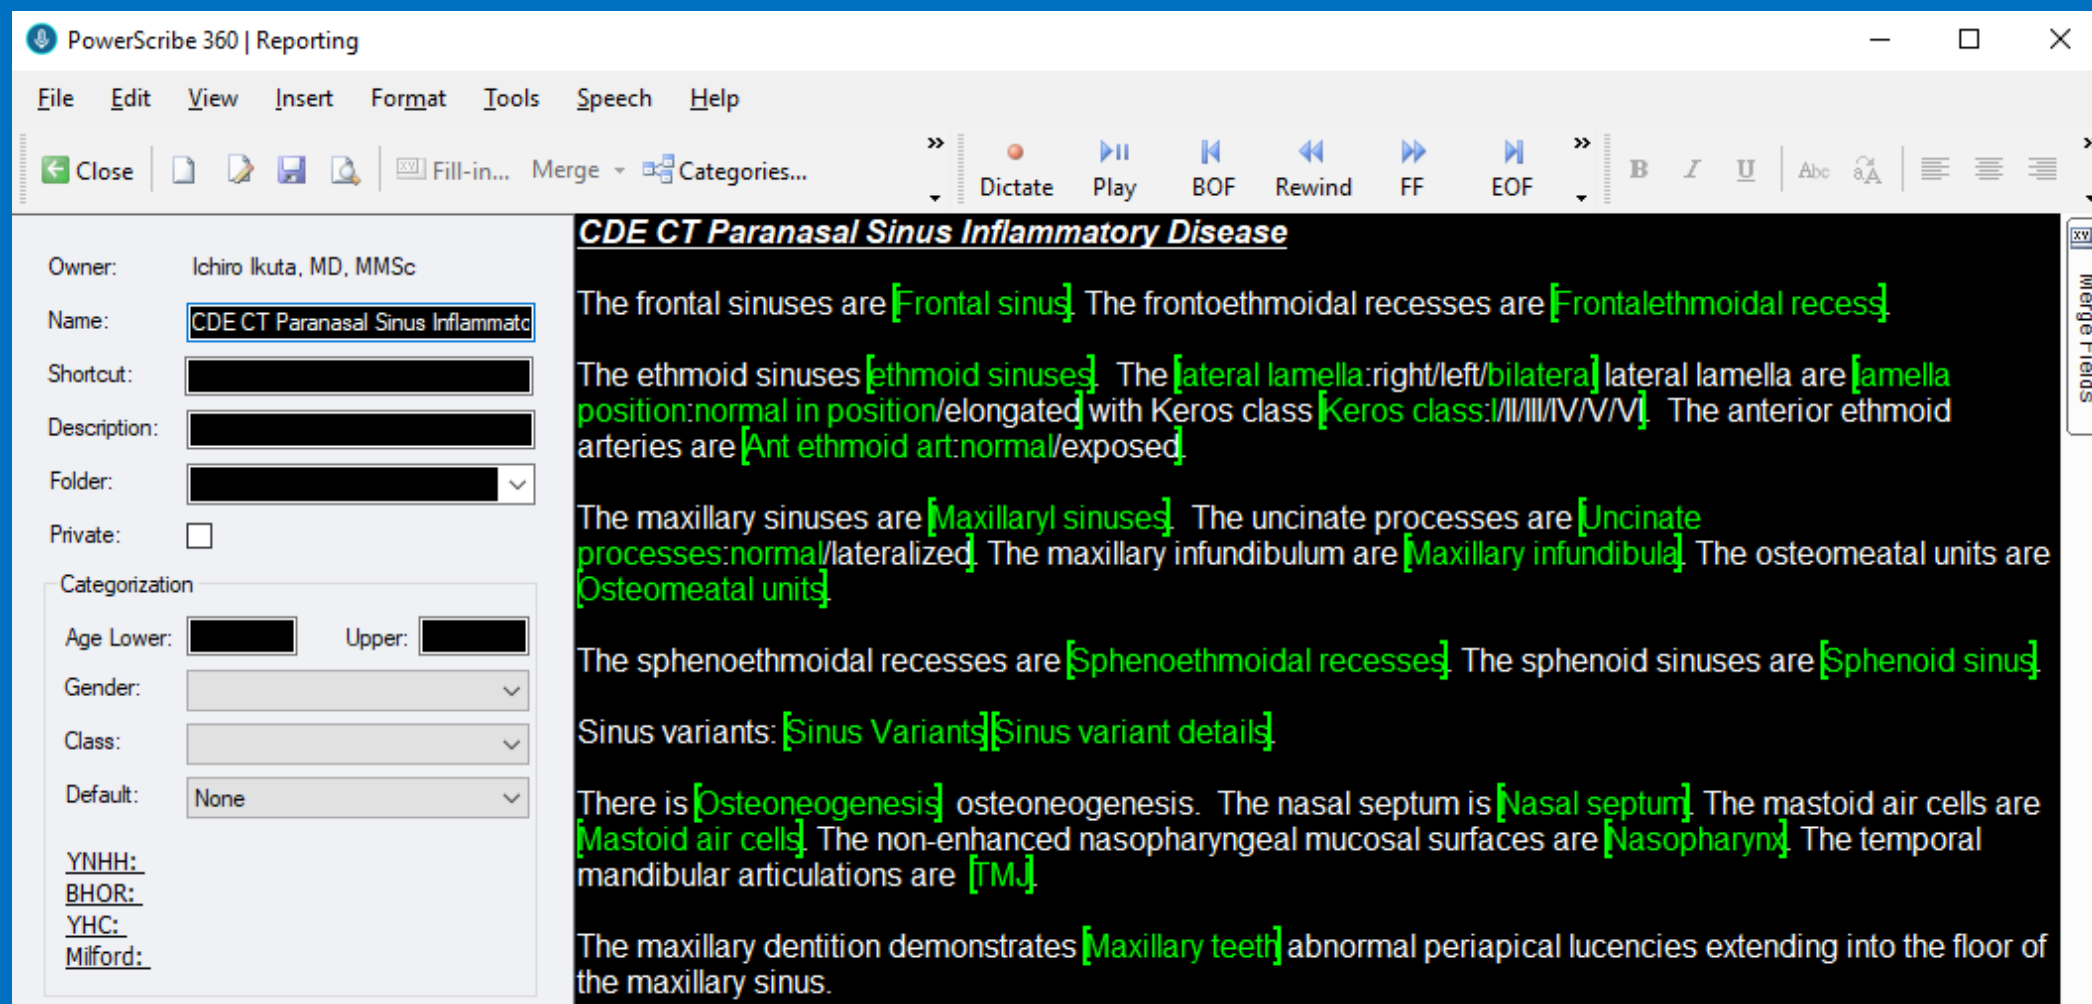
Original ASNR-ACR-RSNA CT Paranasal Sinus Inflammatory CDE Macro. [Text within brackets represent fields for free response and/or selection from Pick Lists].
